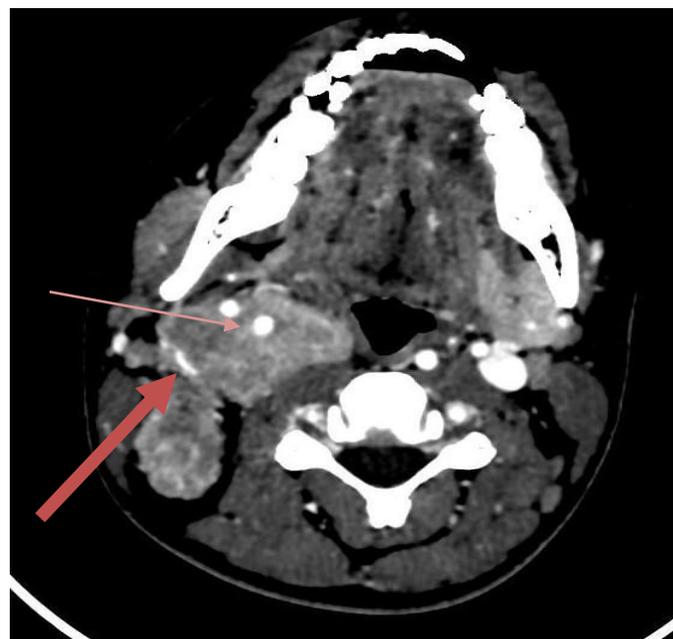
Contrast CT image shows the lesion exhibiting moderate post contrast enhancement with encasement of the carotid bifurcation (thin arrow) and displacement of the carotid arteries anteriorly as well as compressed IJV (thick arrow) posterolaterally.
